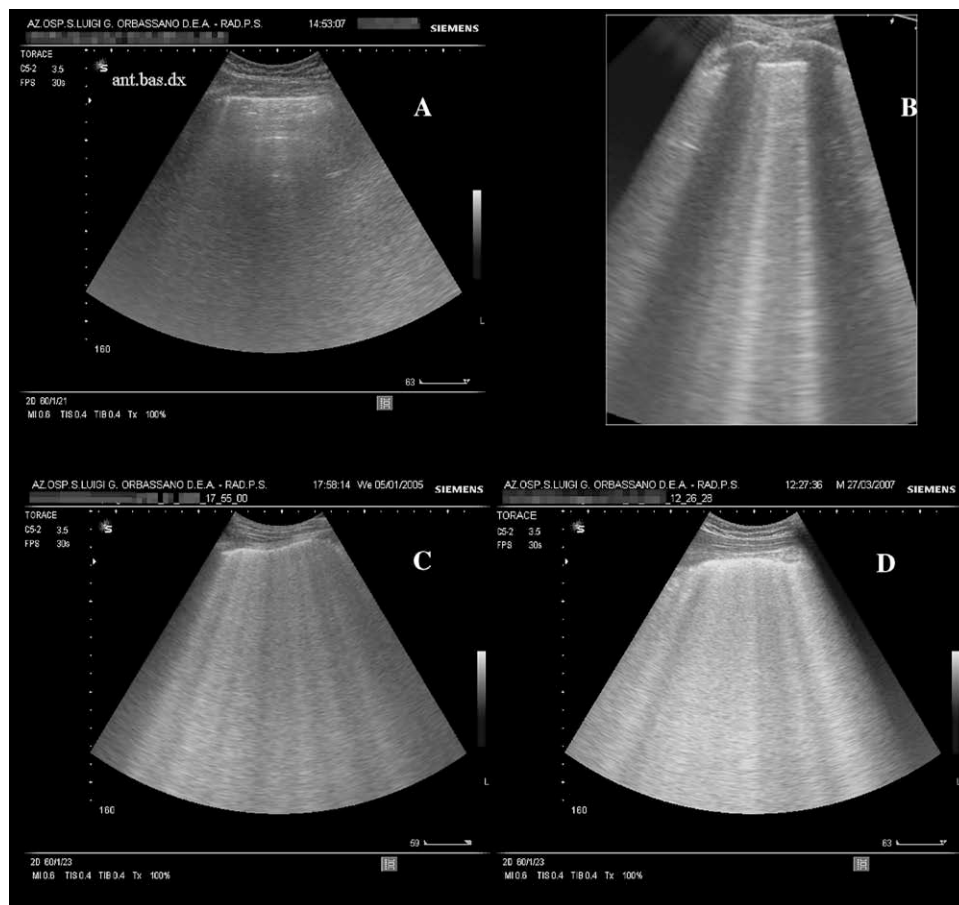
A, Normal transthoracic ultrasound (US) lung scan with no vertical artifacts (comet tails or B lines). B, Longitudinal US lung scan for the detection of the pleural line between 2 adjacent ribs ("bat sign"). C, Oblique transthoracic US lung scan with B+ in a patient with ADHF. D, Multiple and large B lines that fuse ("shining" or "white" lung) in a patient admitted with ADHF and advanced pulmonary edema.
